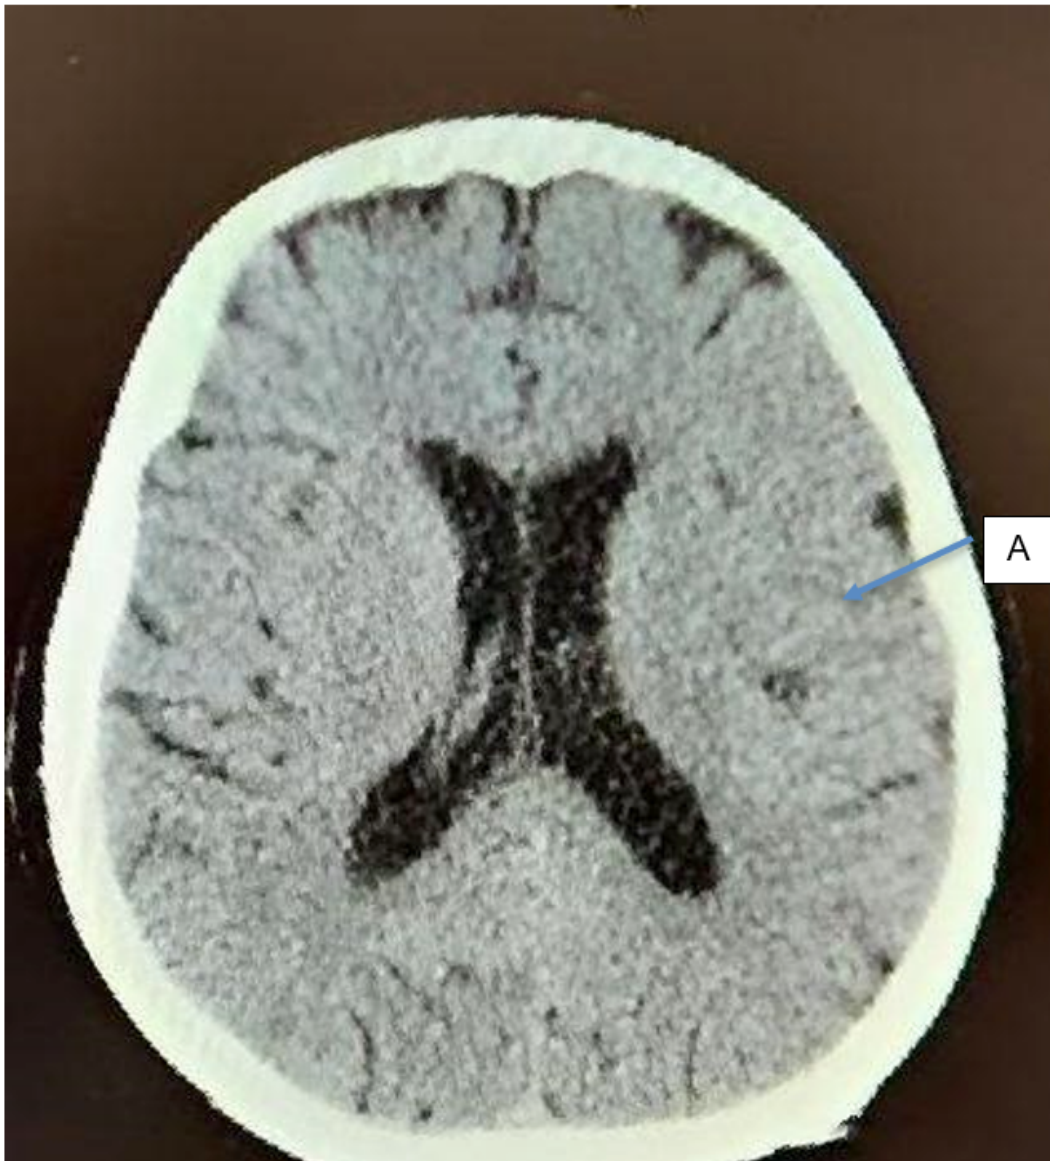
Cerebral CT scan showing the subcapsular ischemic lesion A
